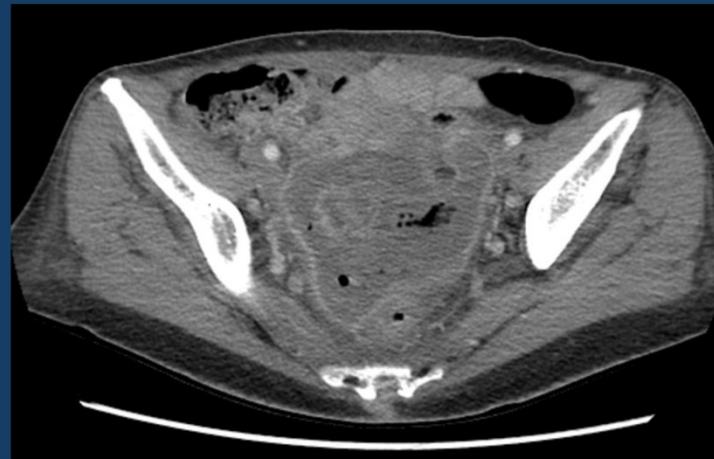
Pre-operative transverse CT shows diverticulitis, a 10.6 x 6cm abscess, and free air
